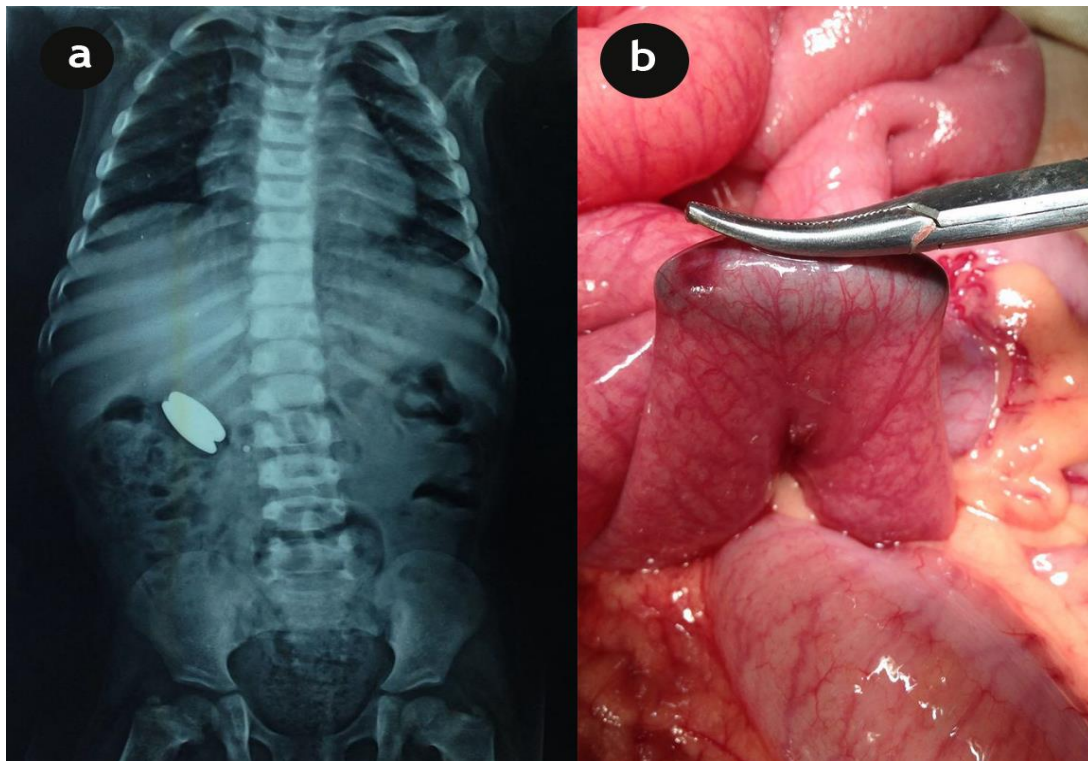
Two ingested magnets. (a) Plain x-ray showing two oblong radio-opaque shadows consistent with magnets sticking together; (b) Intraoperative finding of one magnet in a loop of the small bowel and the other in another loop.
